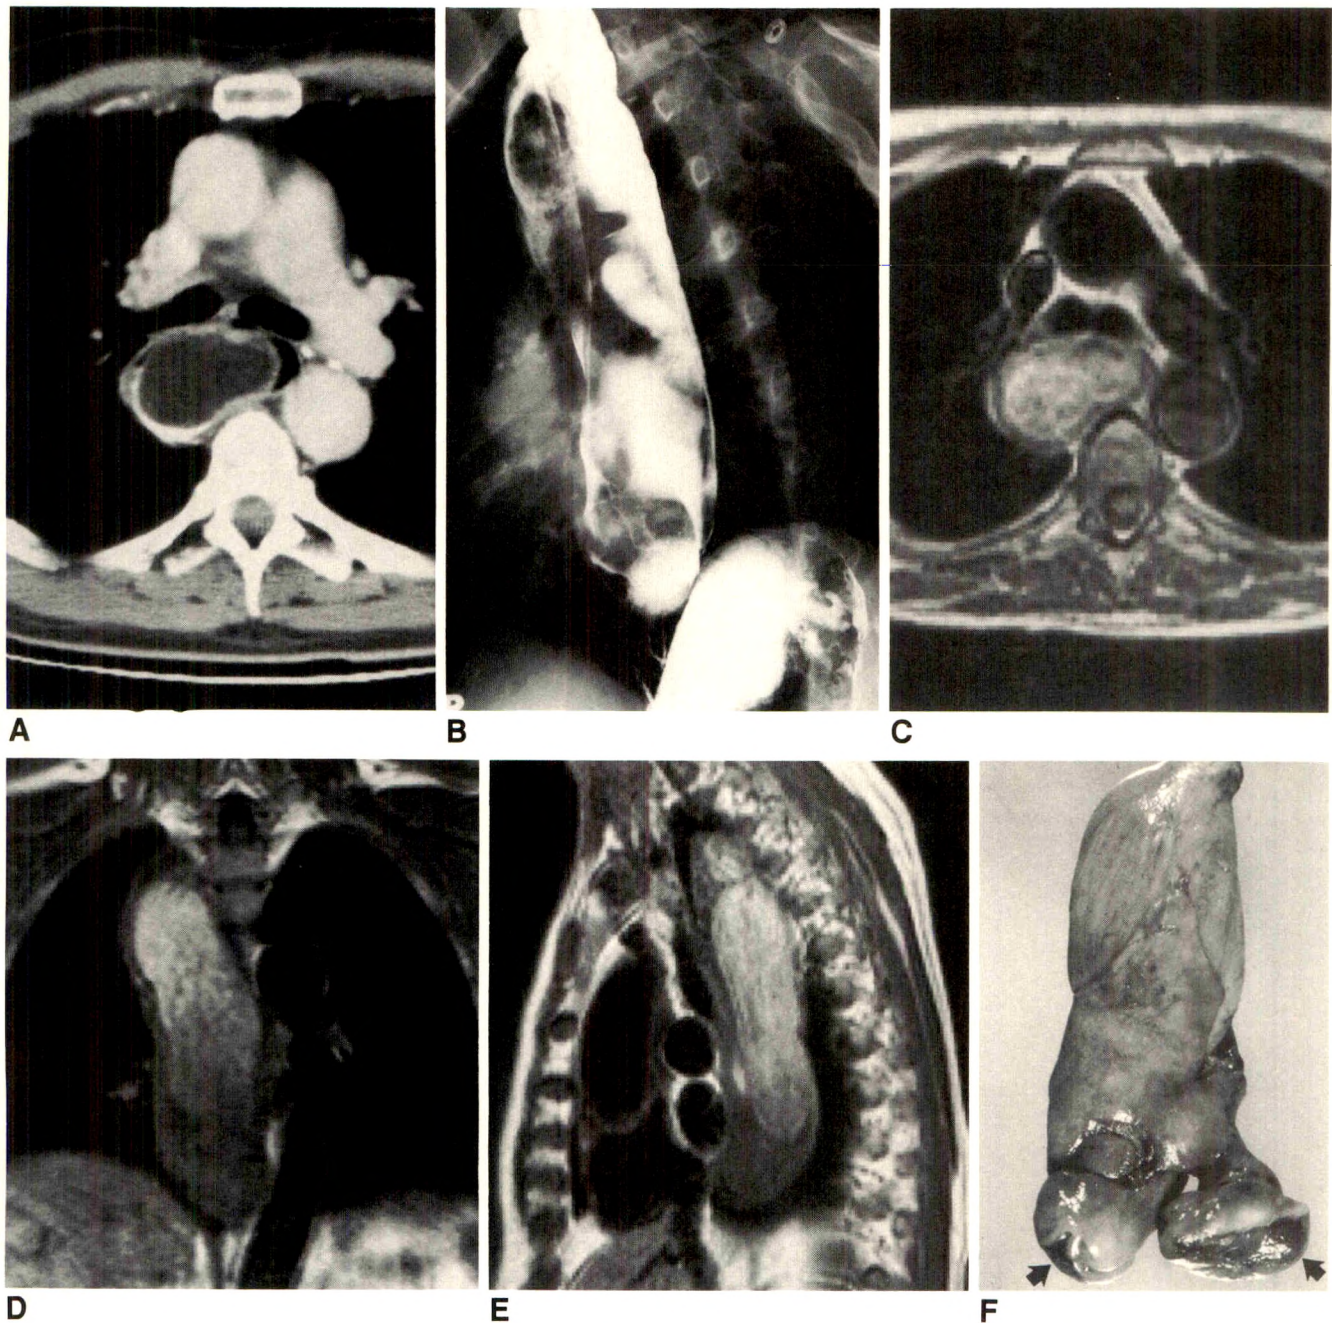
A, Contrast-enhanced CT scan at level of carina reveals posterior mediastinal mass with lipid attenuation. Oral contrast material outlines posterolateral aspect of mass.
